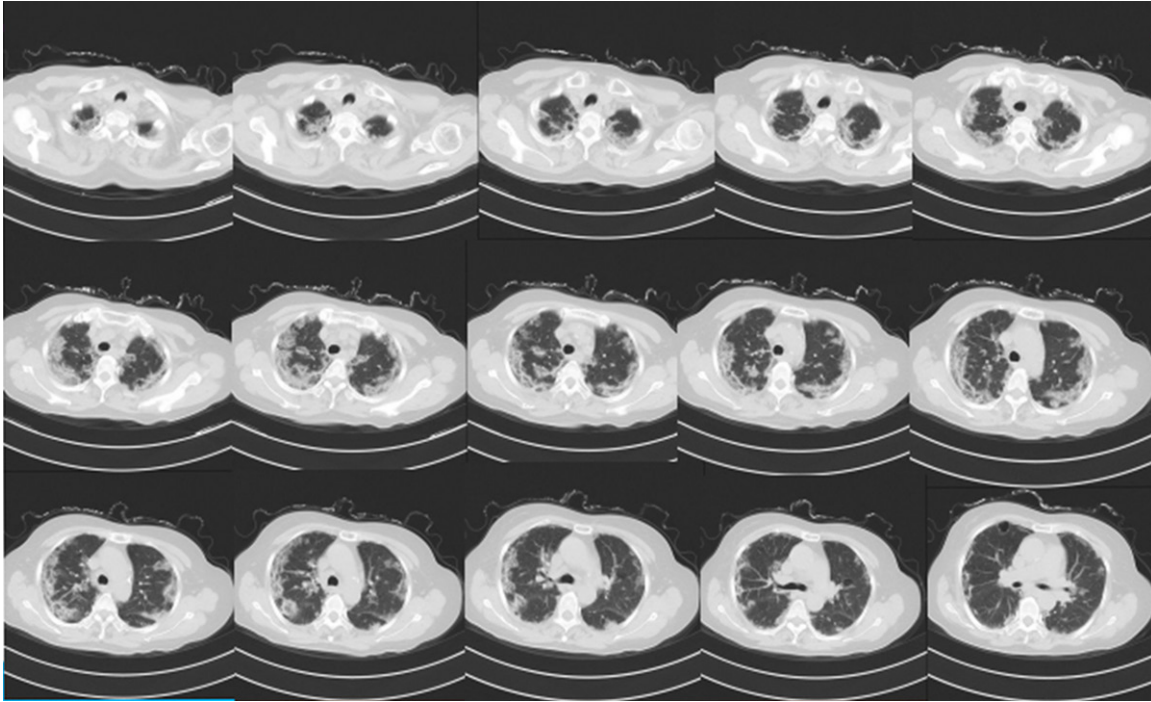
Bilateral lung CT: revealed interstitial changes in both lungs with exudation, multiple pulmonary vesicles in the right lung and multiple mediastinal lymph nodes.
